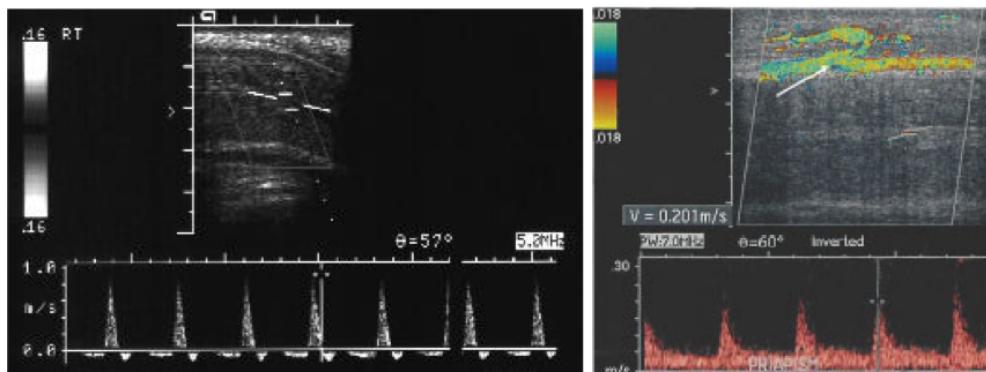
Penile Doppler Penile doppler can be used to distinguish between low flow and high flow priapism. Low flow, when RI > 1.0, represents an emergency necessitating prompt intervention and high flow is represented by RI < 1.0 and does not necessitate prompt intervention.
